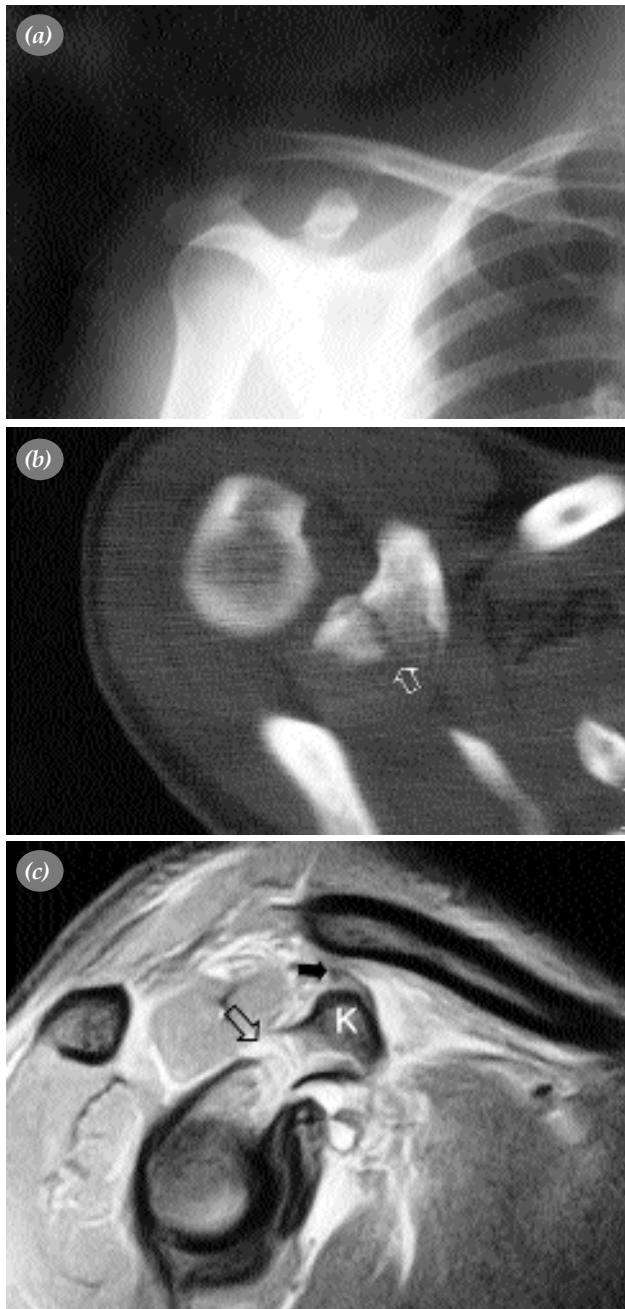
(a). The type 3 AC dislocation and fracture of the coracoid process can be seen in preoperative anteroposterior plain film of the right shoulder. The distance between clavicle and coracoid process is normal. (b). Computed tomography scan. The fracture line goes to base of the coracoid process. (c). Fracture line (empty arrow) of coracoid process (K) and intact CC ligaments (filled arrow) can be seen in magnetic resonance image.
